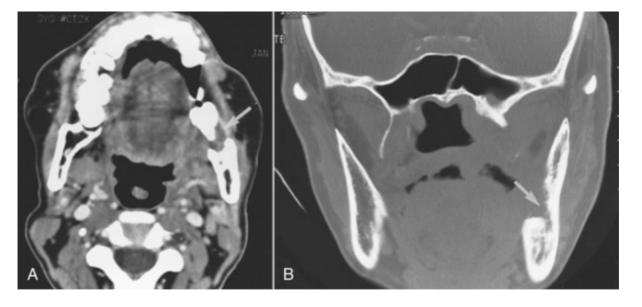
A and B, Computed tomography scans of a patient with retromolar squamous cell carcinoma that eroded the mandible and enveloped the molar tooth (*arrows*).
